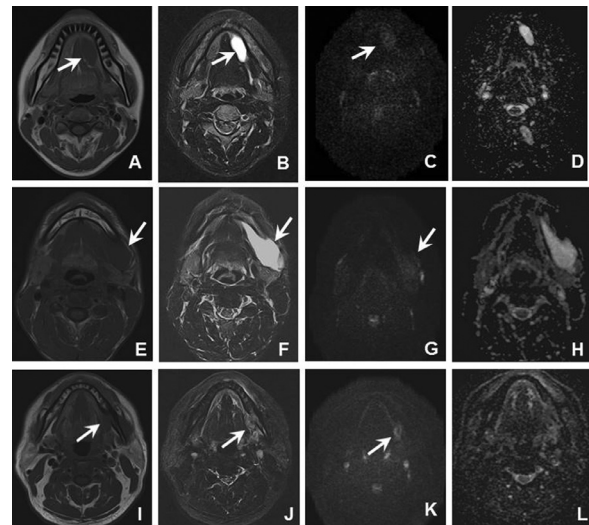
Simple ranulas (A, B, C, D), plunging ranulas (E, F, G, H), and squamous cell carcinomas (I, J, K, L) on MRI. T1WI (A), STIR (B), and DWI (C) show well-defined masses confined to the sublingual space (arrow). A homogeneous low signal is seen on T1WI, with high signals on STIR and DWI (A, B, C). The ADC map of simple ranulas (D) shows a value of $2.46 \times 10^{-3} \text{ mm}^2/\text{s}$. T1WI (E), STIR (F), and DWI (G) show well-defined masses in the sublingual and submandibular spaces (arrow). A homogeneous low signal is seen on T1WI, with high signals on STIR and DWI (E, F, G). The ADC map of a plunging ranula (H) shows an ADC value of $2.73 \times 10^{-3} \text{ mm}^2/\text{s}$. T1WI (I), STIR (J), and DWI (K) show unclear and irregular masses in the sublingual and submandibular spaces (arrow). Squamous cell carcinomas had heterogeneous high signal intensity on STIR and DWI (I, J). The ADC map of a squamous cell carcinoma (L) shows an ADC value of $0.93 \times 10^{-3} \text{ mm}^2/\text{s}$. ADC, apparent diffusion coefficient; DWI, diffusion-weighted imaging; MRI, magnetic resonance imaging; STIR, short-T1 inversion recovery; T1WI, T1 weighted imaging.
